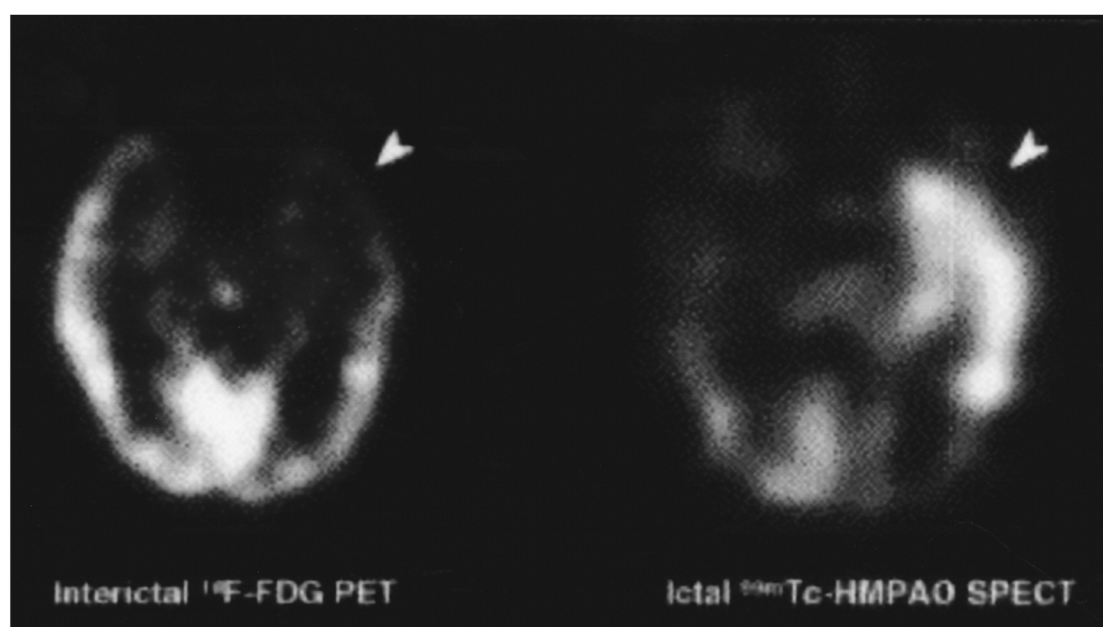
Focal hypometabolism on interictal PET and focal hyperperfusion on ictal SPECT in a patient with left temporal lobe epilepsy. Reprinted with permission from Ho et al., 1995.
